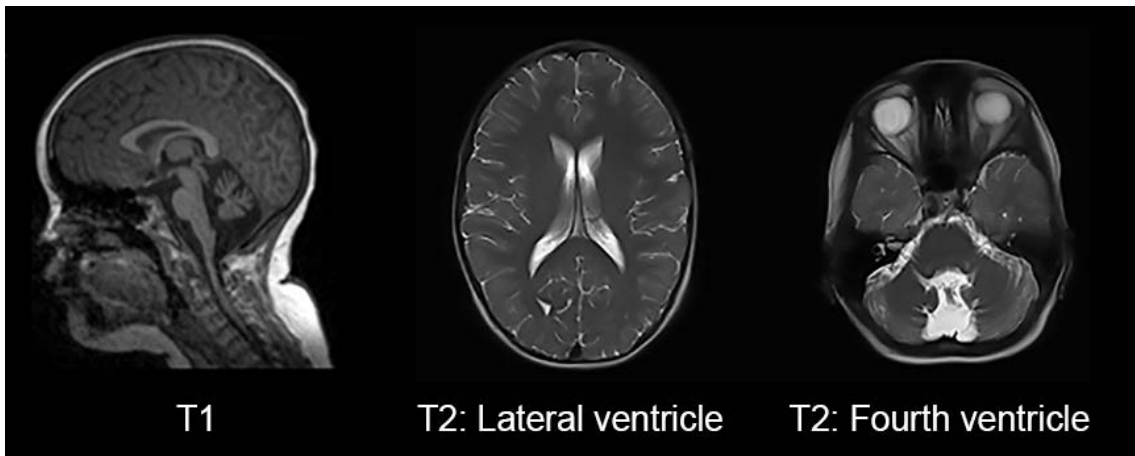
Sagittal T1-weighted (Left) and axial T2-weighted (Middle and Right) structural images of an ataxia-telangiectasia patient. T2-weighted images picture the lateral and fourth ventricles of the brain respectively.
